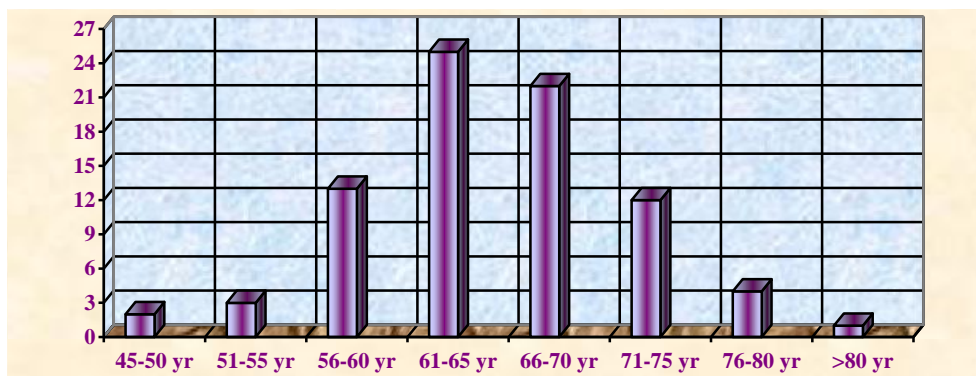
Age distribution of all the patients examined by means of Doppler prior to carotid stenting with angioplastics
